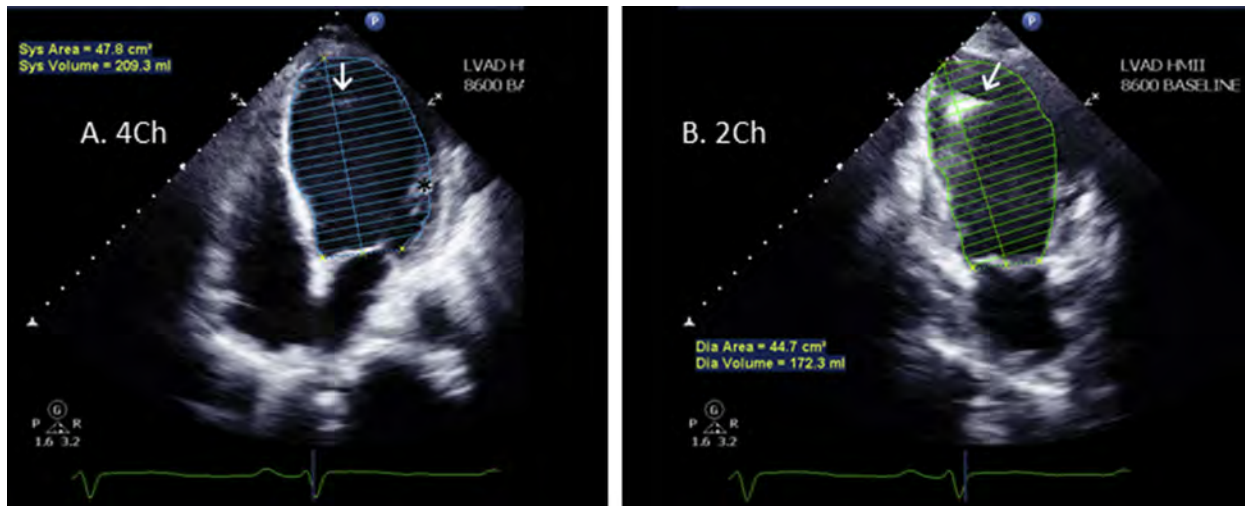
LVEDV, as measured by Simpson's bi-plane method of disks, is preferred for LV size assessment when possible. Simpson's single-plane LVEDV method (using the best/least-foreshortened (A) 4-chamber [4Ch] or (B) 2-chamber [2Ch] view) may suffice for LV size assessment and may be superior to linear measurements (eg, [Figure 15](#)). The inflow cannula (arrow) and anterolateral papillary muscle (*) are excluded from the endocardial tracing. Note: In view B, aneurysmal remodeling of the LV apex (relative to the LV base), which would cause underestimation of LV size by parasternal long-axis-view linear measurements (eg, [Figures 15A,B](#)). See also [Videos 21](#) and [22](#).
